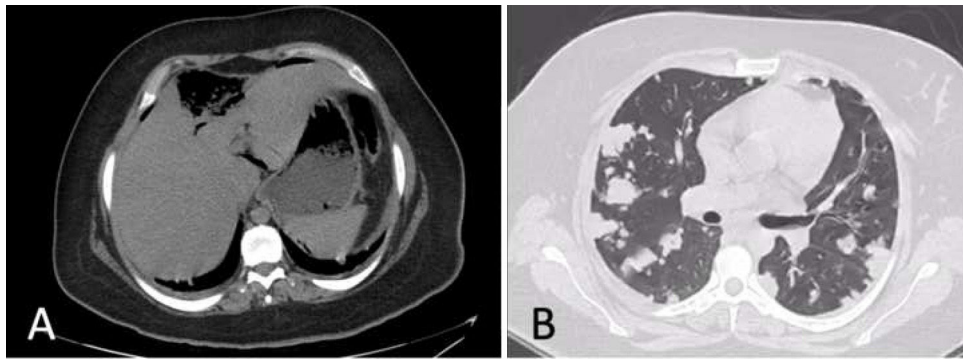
A) Abdominal CT scan showing a ruptured liver abscess. B) Chest CT scan showing multiple bilateral cavitated nodules.
